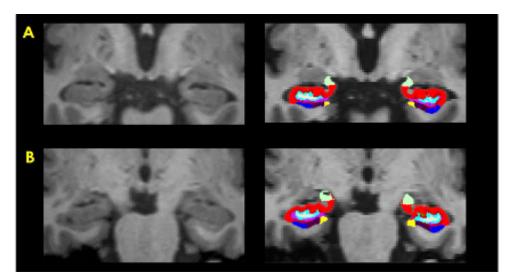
Coronal view MRI bilateral hippocampi of a 72-year-old male with mild cognitive impairment (amyloid PET positive) (A), and a 68-year-old male with first diagnosis treatment-naïve MDD (B) shown in T1-weighted image (left), and T1-weighted image with subfield hippocampal segmentations (right).
